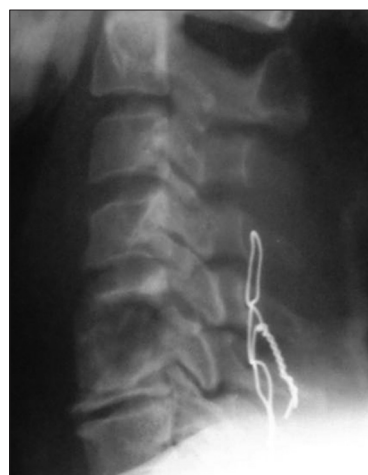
Cervical spine X-ray [lateral view] of a patient who had interspinous wire (Rogers technique^[6]) after an anterior corpectomy with no evidence of canal penetration
